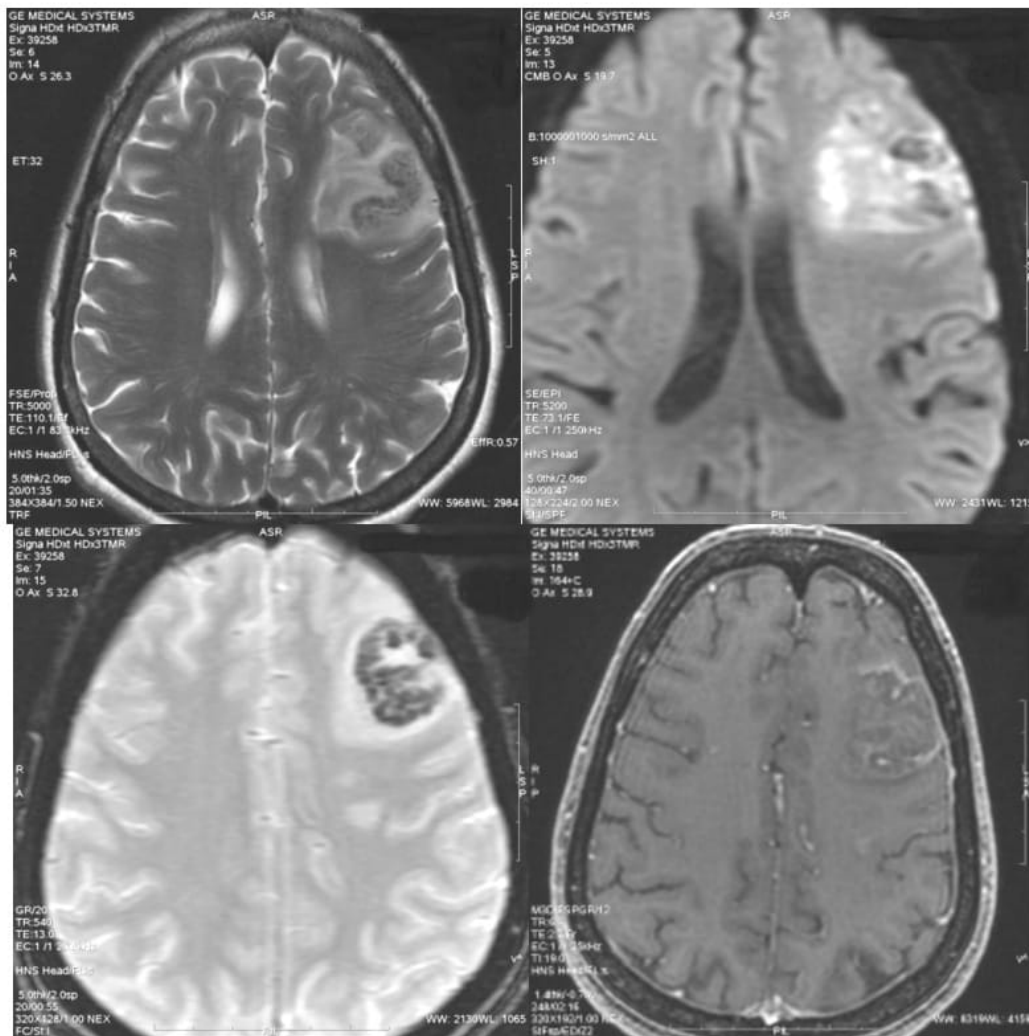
53 year old female presented with new onset seizures imaging showed left frontal subacute infarct with hemorrhagic conversion, cortical laminar necrosis involving middle & inferior frontal gyri. Wedge shaped left frontal T2/FLAIR hyperintense lesion involving grey & white matter (a) with areas of diffusion restriction (b) & blooming in gradient images involving middle & inferior frontal gyri is noted (c). Linear gyral T1 hyperintensities noted. Gyral enhancement and effacement of sulci. (d)- Image number start from top a to d bottom
